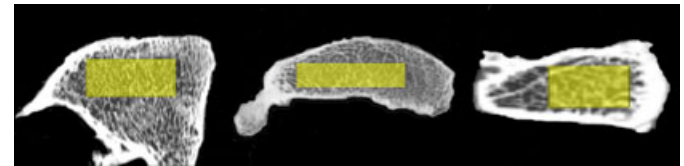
VOI defined in antero-posterior (left), medio-lateral, and supero-inferior (right) planes for a CT reconstruction.
